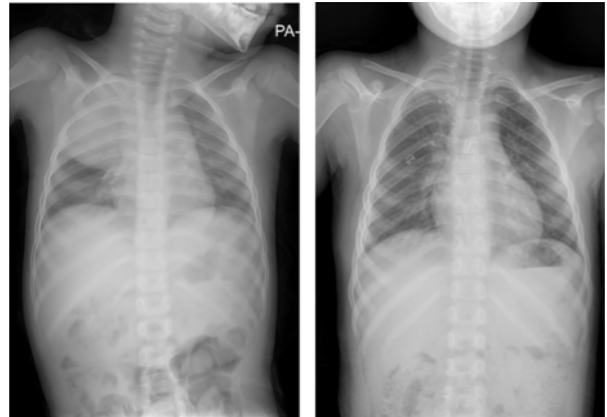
Preoperative and postoperative postero-anterior lung radiographs of the patient.
